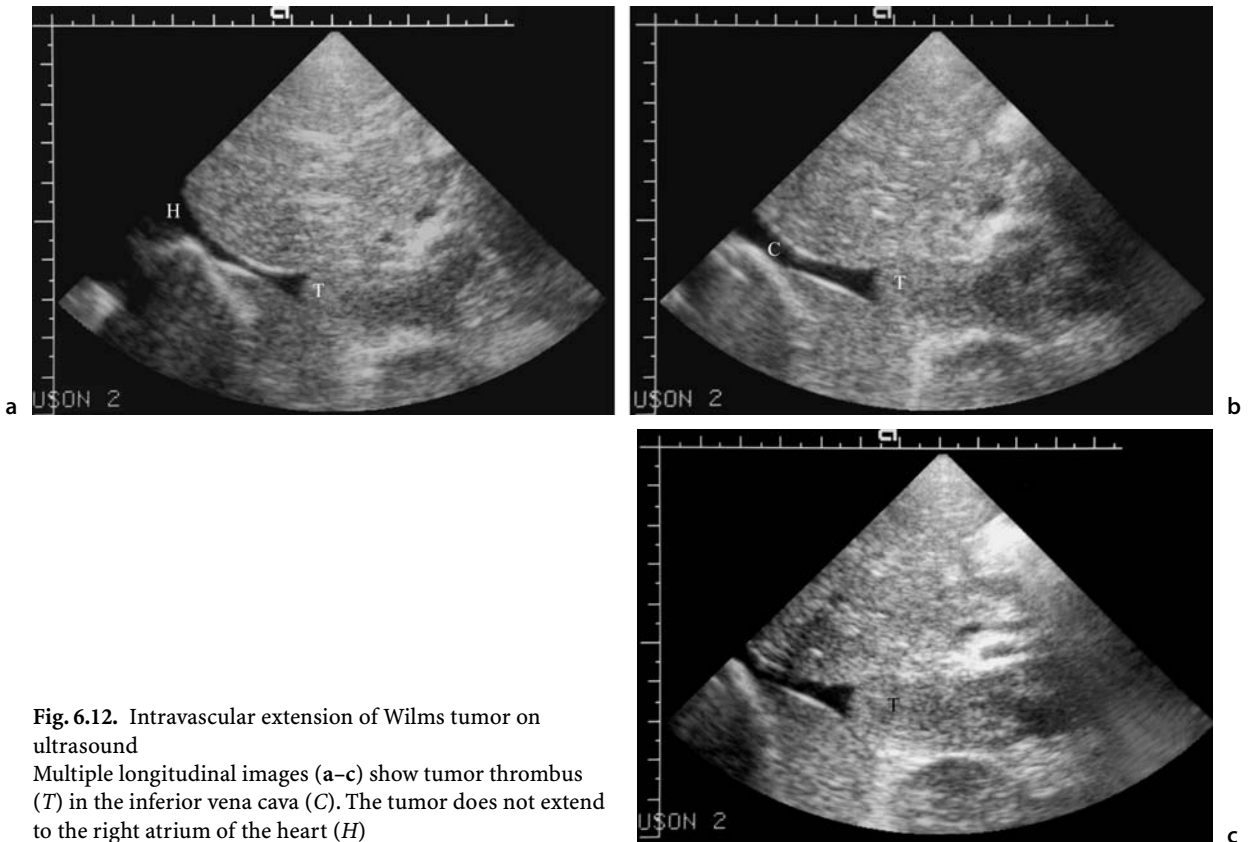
Intravascular extension of Wilms tumor on ultrasound
